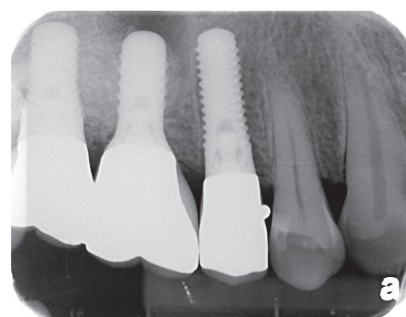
Periapical radiograph taken after temporary cementation of the crown.
